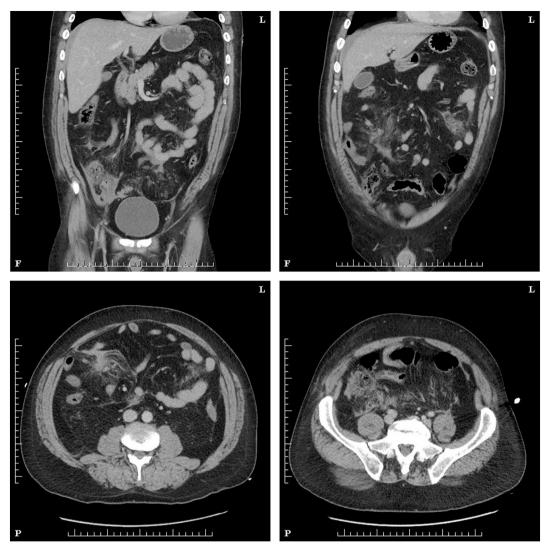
Coronal and Sagittal CT imaging demonstrating mesenteric hematomas and intestinal injury.
